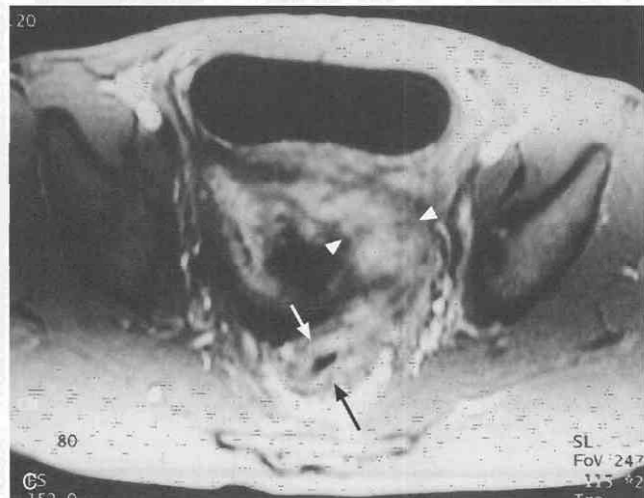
Crohn's disease with enterorectal fistula. A, Small-bowel follow-through examination shows an enterorectal fistula (*arrow*). B, CT scan shows diffuse pericolic, perirectal, and perienteric inflammatory infiltrates with bowel wall thickening of pelvic ileal loops. C, Gadolinium-enhanced MR image shows marked contrast enhancement in the thickened rectal wall (*arrows*) and inflammatory tissues (*arrowheads*) surrounding the fistula.
